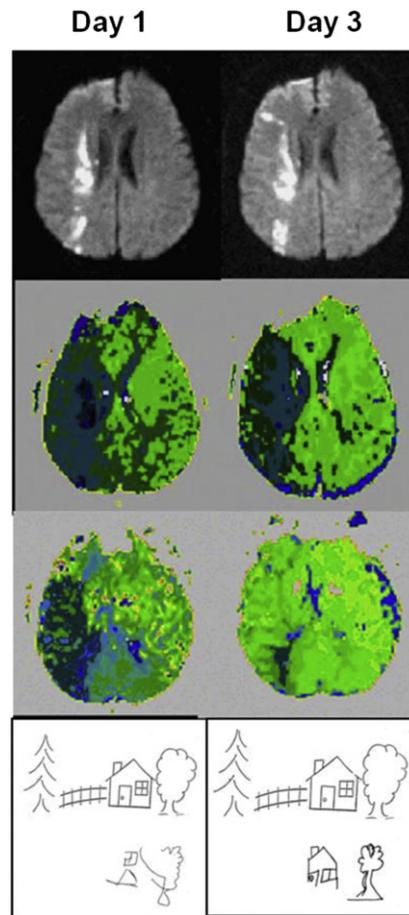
Top panel: DWI scans at Day 1 (left) and Day 3 (right) of Case 1. Middle 2 panels: PWI scans at Day 1 (left) and Day 3 (right) of Case 1. Lowest panel: Copy of the scene at Day 1 (left) and Day 3 (right) by Case 1.
